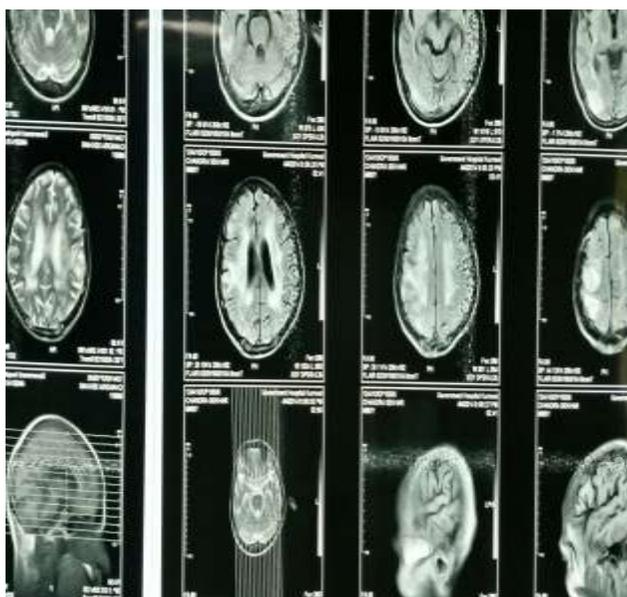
MRI brain showing bilateral deep white matter ischemic changes, bilateral lacunar infarct in both thalami, T2, flair hyper intensities noted in right parieto occipital lobe and right corona radiata s/o acute infarct
